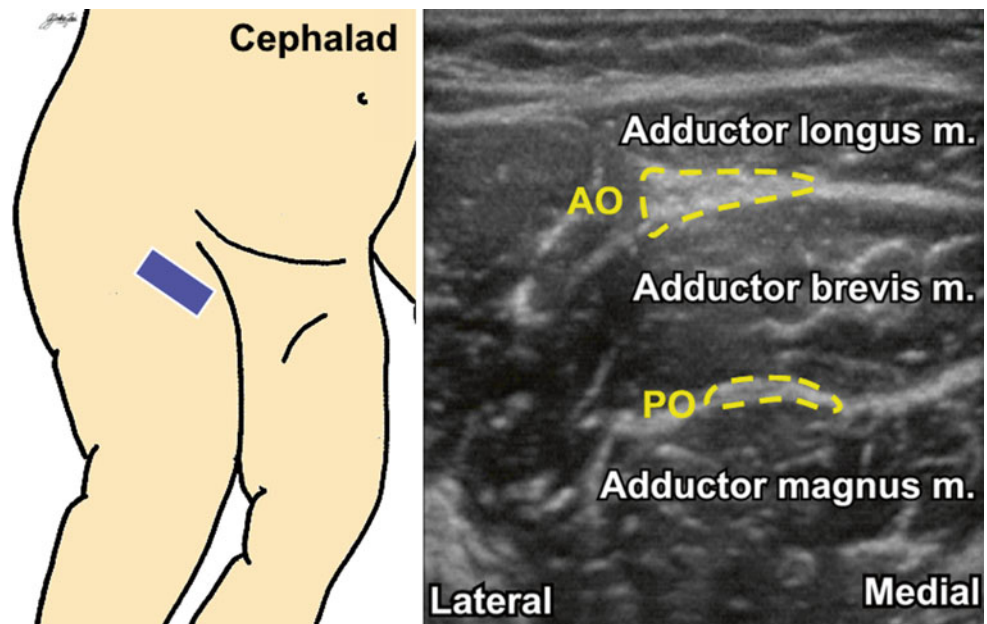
Ultrasound image of the adductor muscles and anterior (AO) and posterior (PO) obturator nerves
